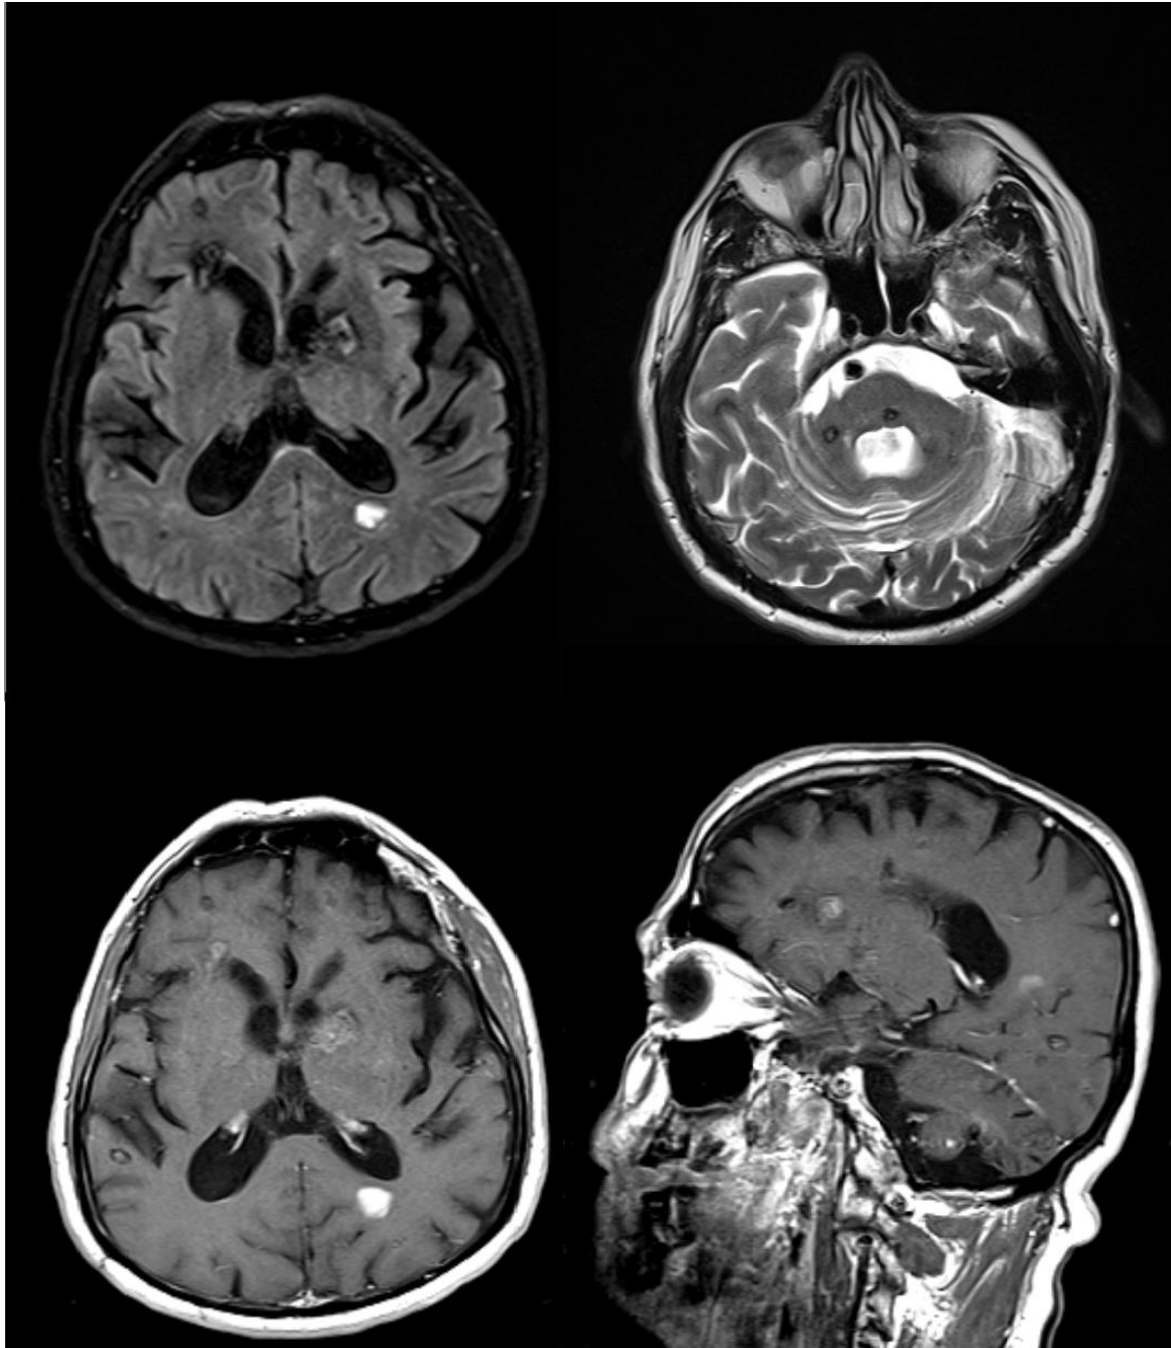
MRI of brain showing hyperintens multiple cysts in T2 weighted sequences; in T1 sequences, contrast enhancing multiple (some of them are calcified) neurocysticerci
